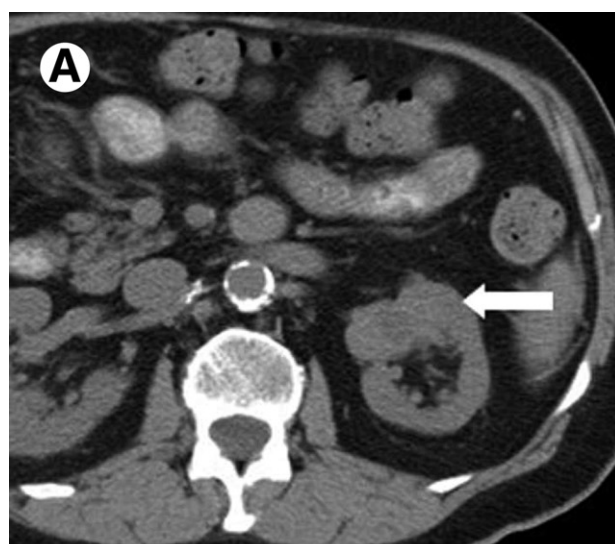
Sporadic papillary RCC. Axial CT images from a dedicated renal mass CT protocol shows a papillary RCC. (A) Noncontrast image shows an iso-hypodense left renal mass (arrow). (B) Corticomedullary and (C) nephrographic phase images demonstrate mild internal enhancement within the lesion (arrows).
